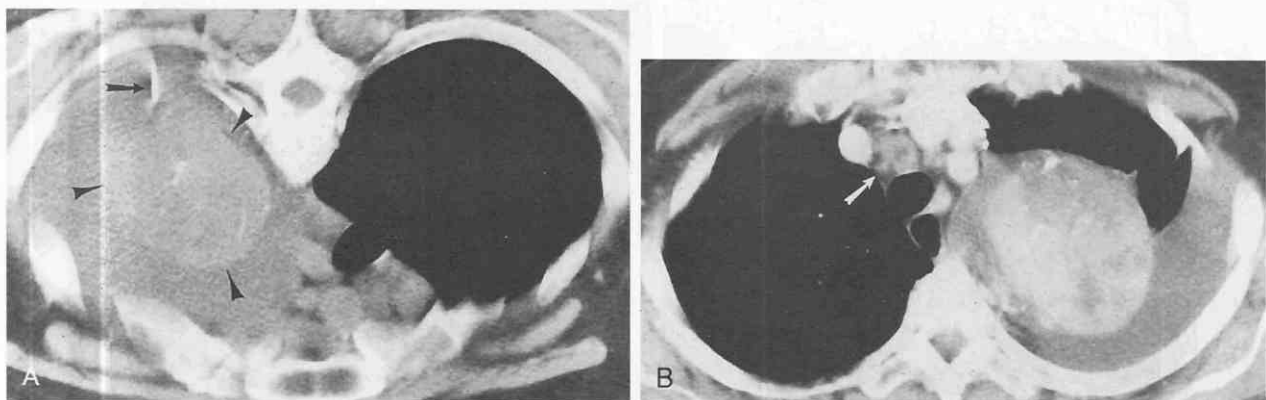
Hyaline-vascular Castleman's disease. A, CT performed to direct a biopsy on a patient in the prone position shows heterogeneous soft-tissue-attenuation mass in the left posterior mediastinum (arrowheads). The biopsy needle (arrow), central linear calcification, and left pleural effusion can be seen. B, Contrast-enhanced CT with the patient supine shows intense enhancement within the mass as well as a small associated pretracheal node (arrow).
